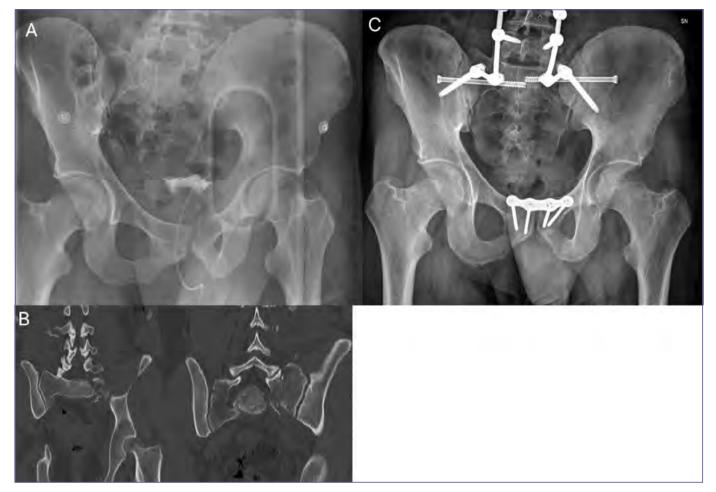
A) a Tile C1 fracture in shock room; B) a coronal reconstruction of CT scans where a right sacral ala fracture is observed; C) definitive treatment with pubic plate and two right sacro-iliac screws.
